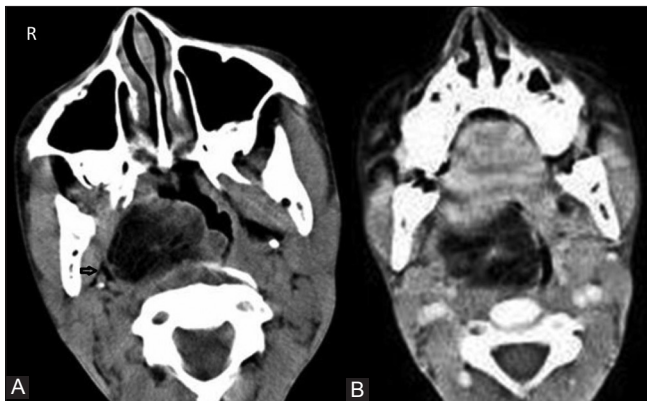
(A and B): Axial Plain and Contrast CT image of the neck shows hypodense mass lesion (predominantly fat attenuation) in right pharyngeal wall with displacement of prestyloid fat plane (black arrow). Post contrast image shows linear enhancing bands
